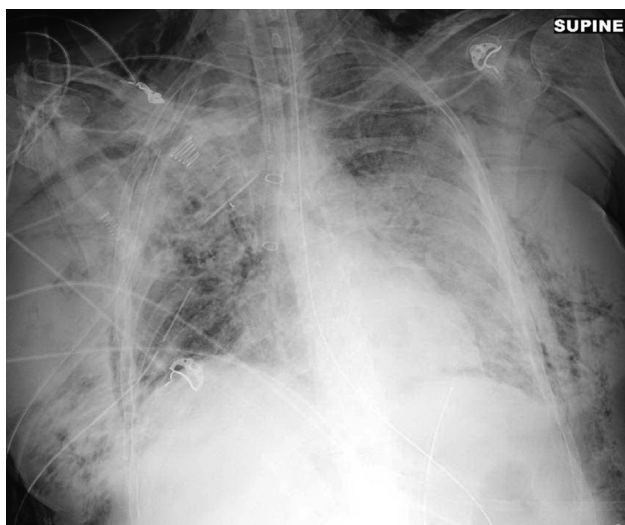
Chest radiograph shows bilateral infiltrates and marked subcutaneous emphysema. Two chest tubes have been placed on the right side. Note that the double lumen endotracheal tube terminates in the right mainstem bronchus.
